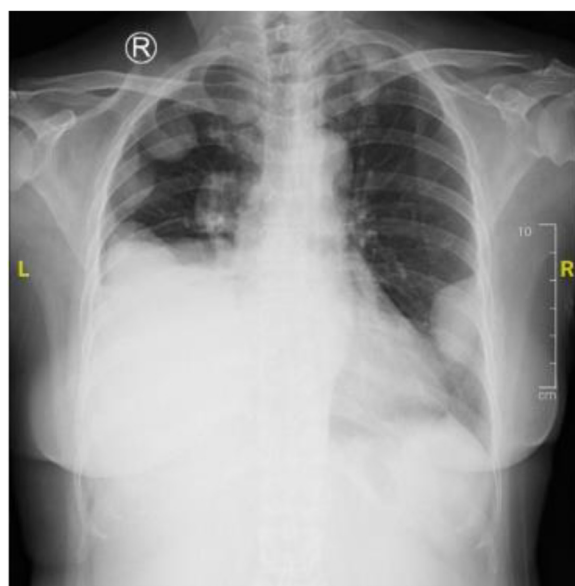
Chest X-Ray with multiple metastasis nodules and right pleural effusion.
